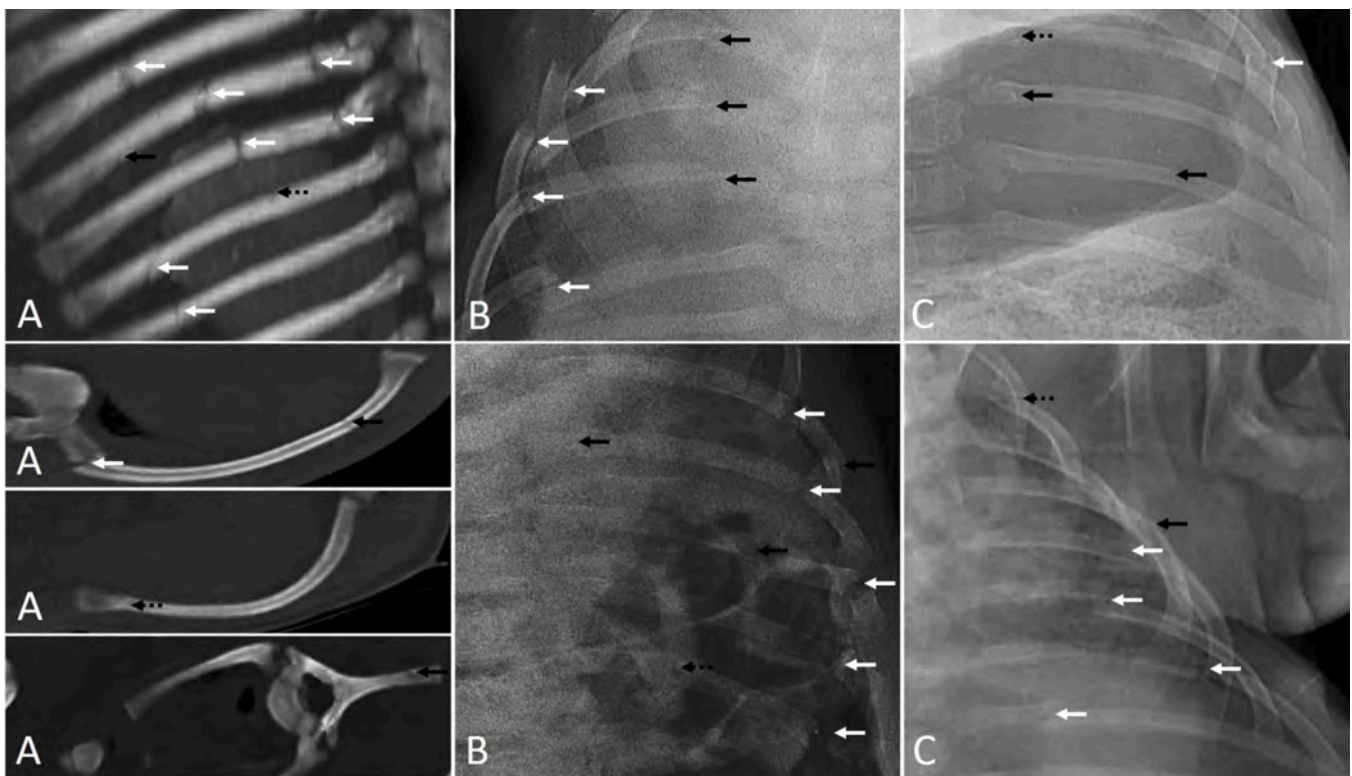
Frequently unidentified fractures of the ribs and vertebrae as shown with CT (A), X-ray (B) and Lodox® (C) scans. Solid white arrows indicate fractures identified by all observers; solid black arrows indicate fractures identified only by the SRR and NFA; dashed black arrows indicate fractures identified only by the NFA.
